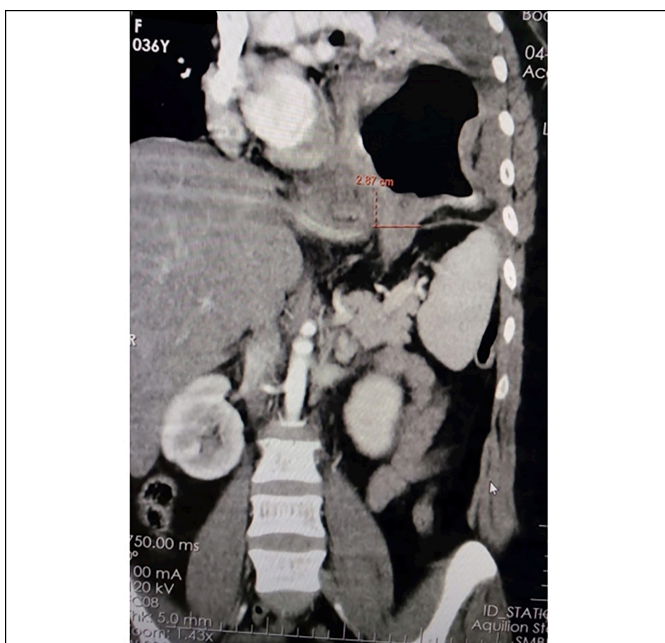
CT-Scan abdomen plain showing herniation of the stomach into the left haemithorax with a breach in the left haemidiaphragm of 2.8 cm (coronal view).
